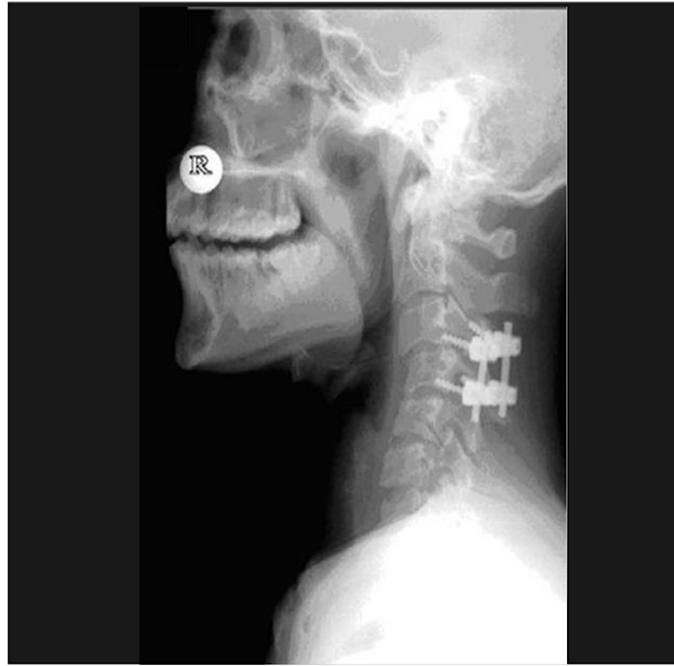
Case no. 2. Plain radiograph of surgical C3-C4 stabilization
